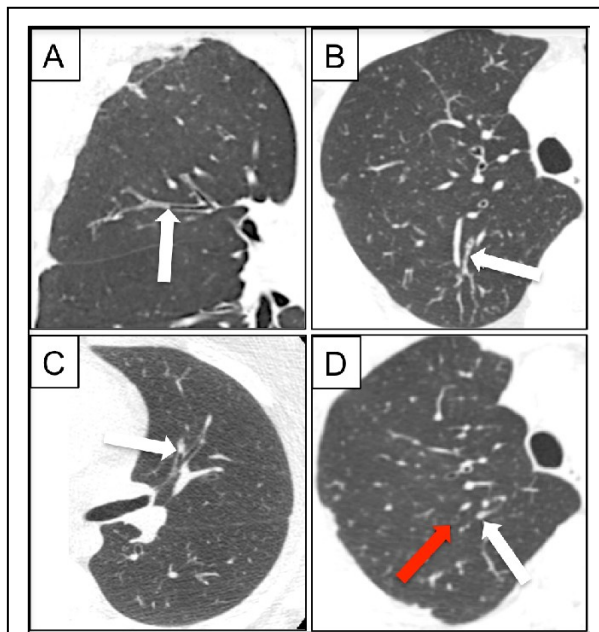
Intraluminal mucus in CT lung images of asthmatics. Mucus plugs in CT scan images (white arrows) were defined as complete occlusion of an airway lumen by mucus and were identified as tubular structures in longitudinal section with branching (A & B) or without branching (C) or as rounded opacities in cross-section (D). The latter were traced cephalad or caudad on adjacent slices to confirm their continuity with unoccluded bronchi (red arrow).
